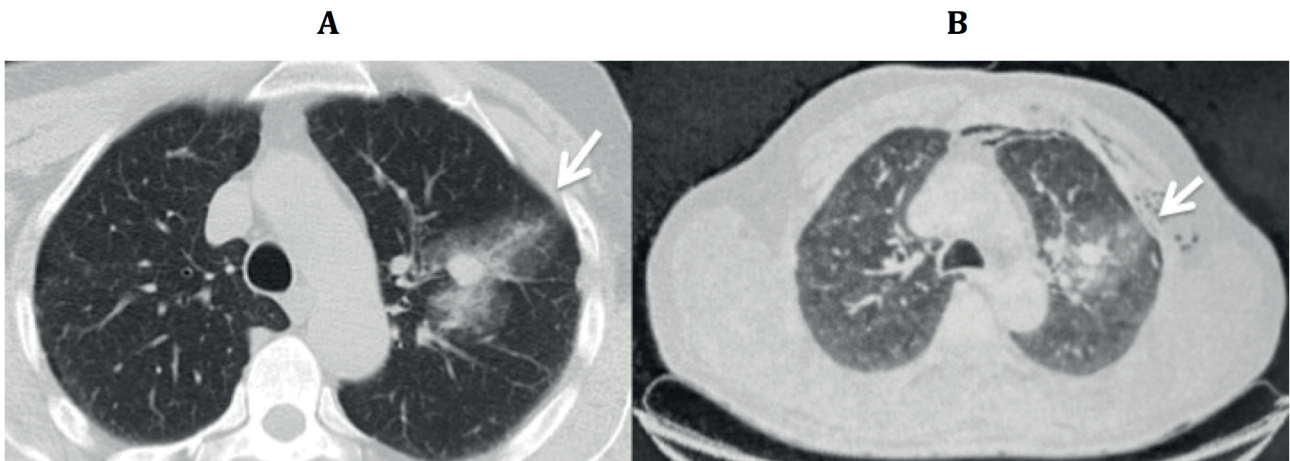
CT (A) and PET (B) scans. PET scan shows SUVmax 3, suggestive of malignancy. The final diagnosis was hamartoma (arrows).
